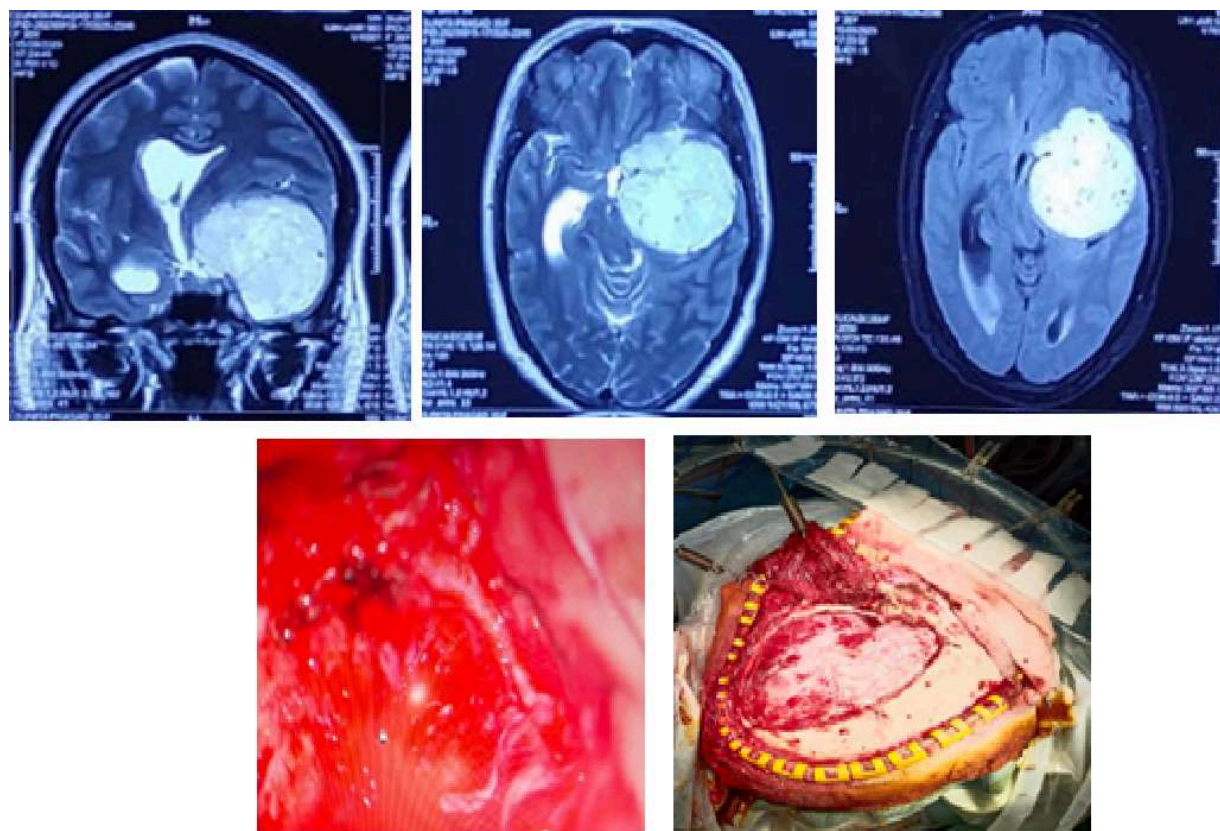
MRI Shows Meningioma originating from the greater wing of the sphenoid (above) and intraop images(below)
